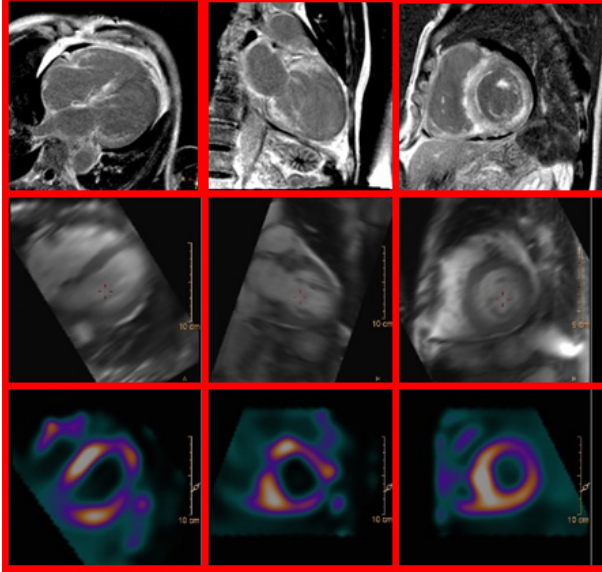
An example of a combination of gadolinium late enhancement on CMR (T1 weighted images in the upper line; T2 weighted in the second line) and ^{99m}Tc diphosphonate scintigraphy (bottom line), which shows a myocardial infiltration.
